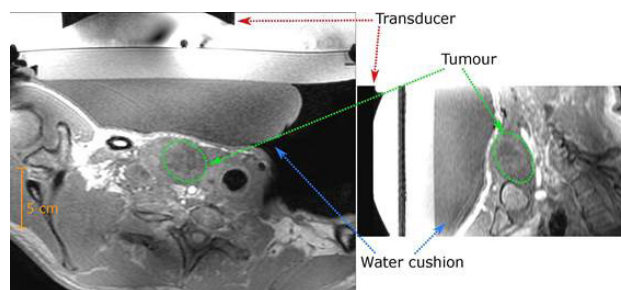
T1-weighted planning imaging showing tumour location, transducer and water cushion. Left) axial view; Right) sagittal view.
